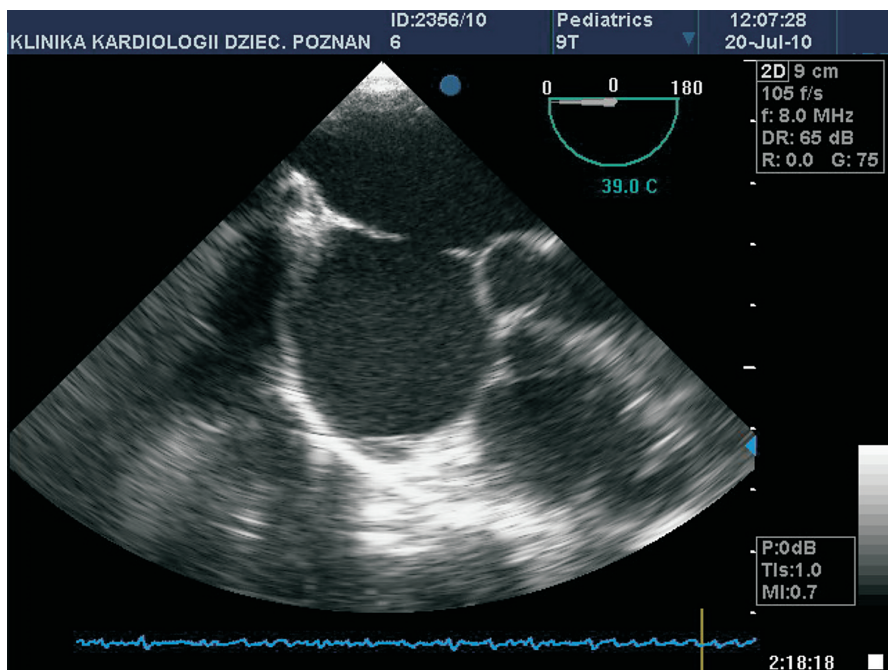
Transoesophageal echocardiography. Ostium secundum atrial septal defect (ASDII)
